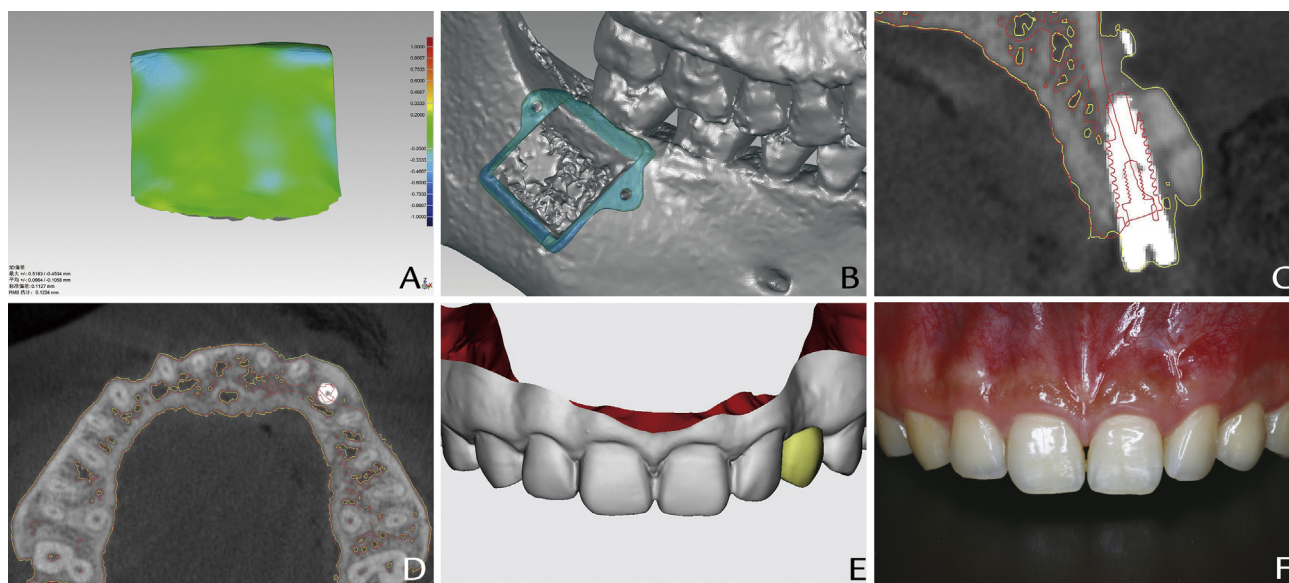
Evaluation and outcomes. A, Three-dimensional, color-coded mapping of differences between selected outer contours of planned and actual grafts. Different colors represent number of deviation ranges (green region represents deviation within ± 0.2 mm). B, Designed osteotomy template is superimposed onto postoperative jaw. C, Postoperative cone beam computed tomography (*red*: preoperative jaw and initially designed implant; *yellow*: outline of maxilla 6 months after bone graft surgery). D, Cross-sectional view of postoperative cone beam computed tomography (*red*: preoperative jaw and initially designed implant; *yellow*: outline of maxilla 6 months after bone graft surgery). E, Original restoration design before bone graft surgery. F, Completed interim restoration, nearly identical to initial restoration design.
